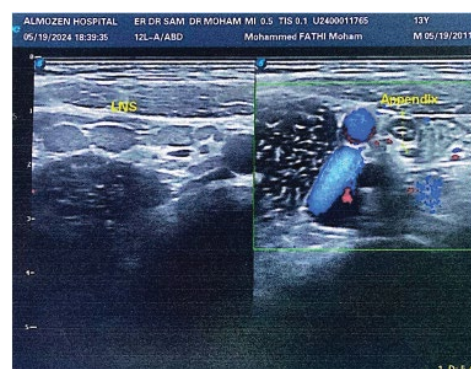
Ultrasound image of the appendix without signs of inflammation
